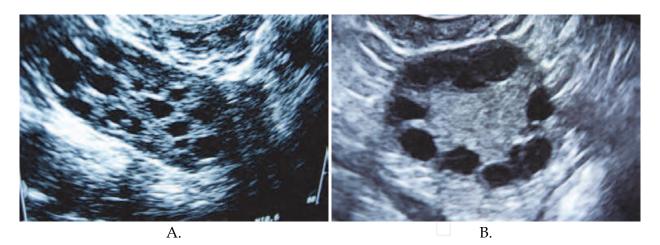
Sonography scans of polycystic ovaries (PCO)- A. central distribution of follicles, B. peripheral distribution of follicles.
